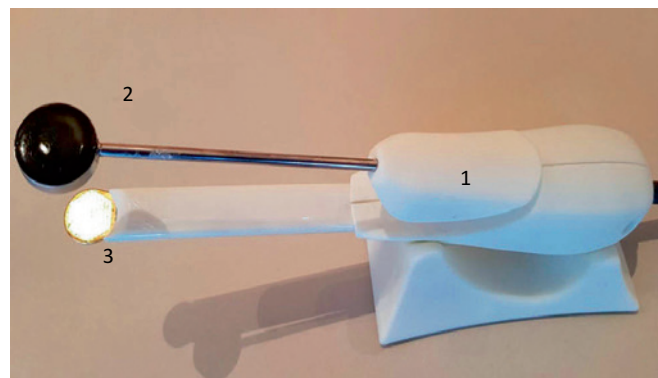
(1) Handpiece with ultrasonic transmitter and receiver unit. (2) Ultrasonic transmitter; (3) Ultrasonic receiver with coplanar and fixed arrangement of transmitter and receiver.
